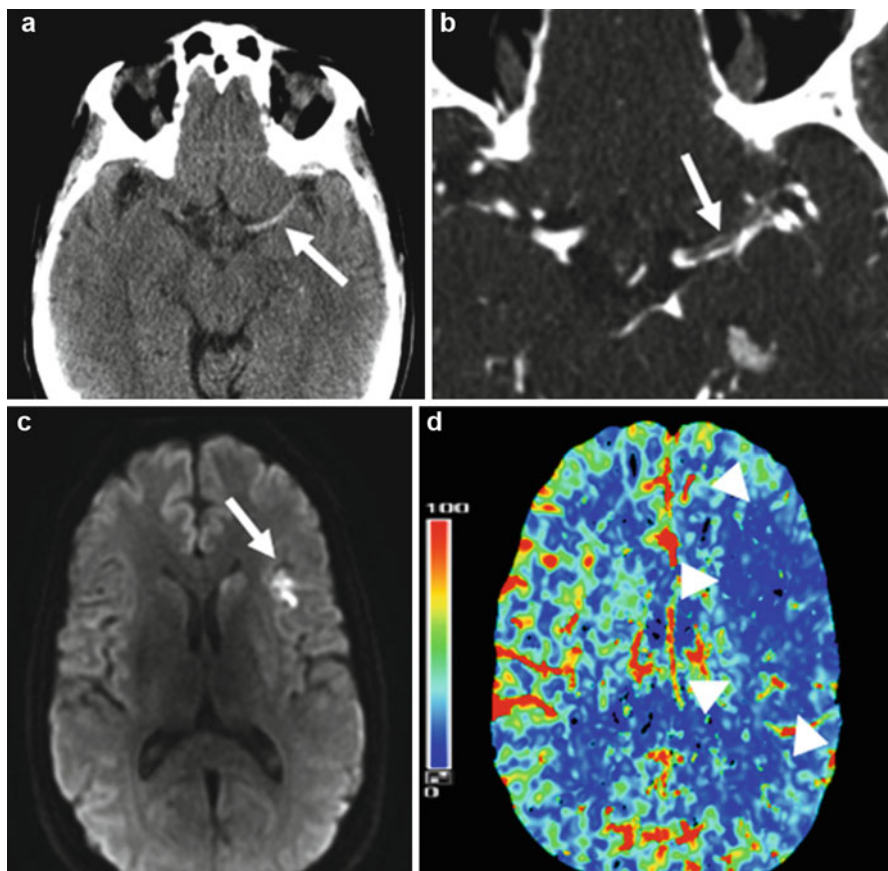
Acute ischemic stroke. (a) Non-contrast CT demonstrates asymmetric hyperdensity within the left middle cerebral artery (MCA) also known as the “hyperdense MCA sign”; this finding is indicative of acute thrombosis, an early sign of ischemic stroke. (b) Contrast-enhanced CT angiography demonstrates the thrombus within the left MCA (*arrow*) resulting in occlusion. (c) DWI shows a small core infarction (*arrow*) within the anterior insula that appears hyperintense due to restricted diffusion secondary to cytotoxic edema. (d) CT perfusion cerebral blood flow (CBF) function map demonstrates a large penumbra of decreased blood flow involving the entire left MCA territory (*arrowheads*) indicative of tissue at imminent risk for infarction
